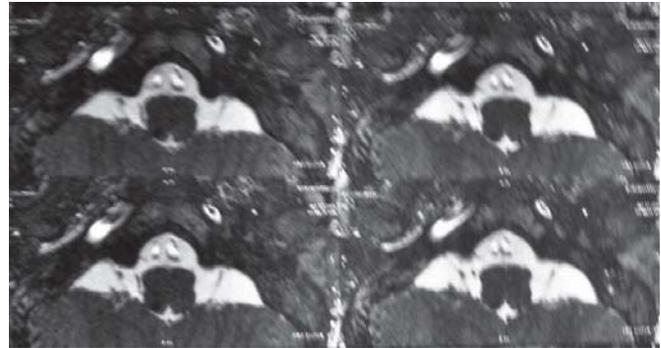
MRI bilateral Michel's deformity
